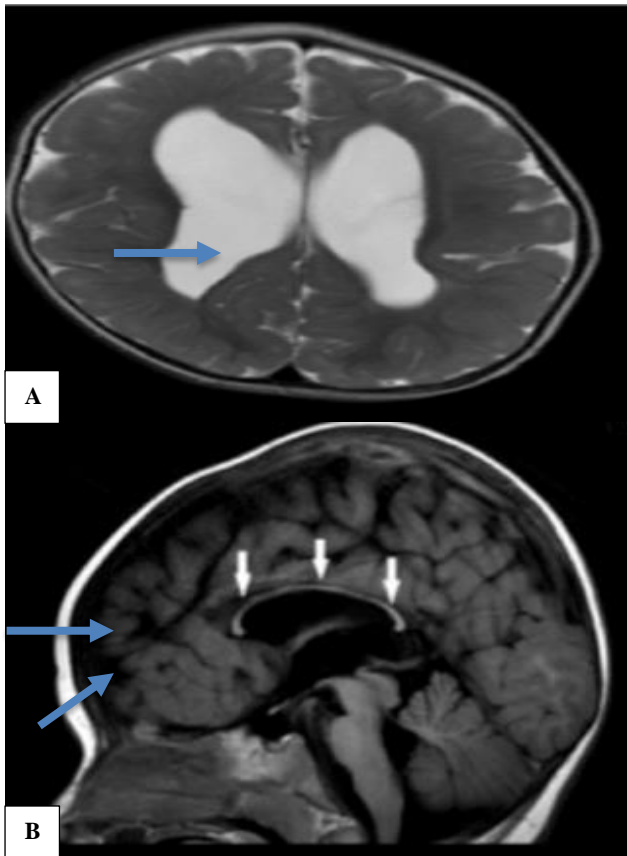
(A and B): MRI brain images in a 10-year-old boy with early onset schizophrenia with bilateral frontal cortical atrophy with corpus callosum thinning and ventriculomegaly; axial T2 weighted MRI showing ventriculomegaly (pointed by blue arrow), sagittal T1 weighted MRI showing frontal cortical atrophy (pointed by blue arrow) with corpus callosum thinning (pointed by white arrows).
